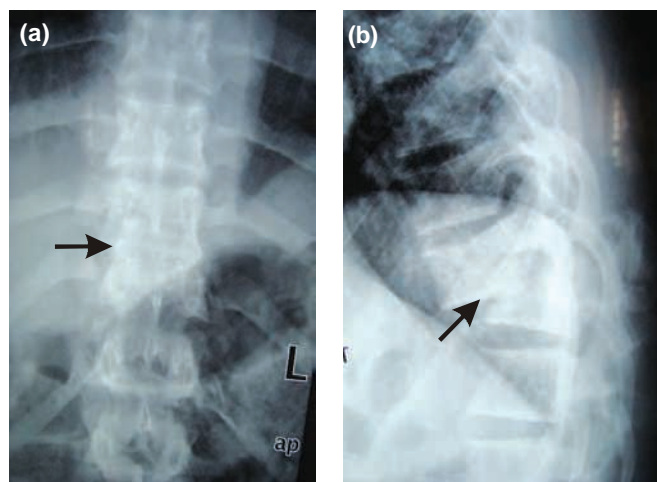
Fracture-dislocation of thoracic spine at T10–T11 level as seen in plain radiograph: (a) anteroposterior view, and (b) lateral view
